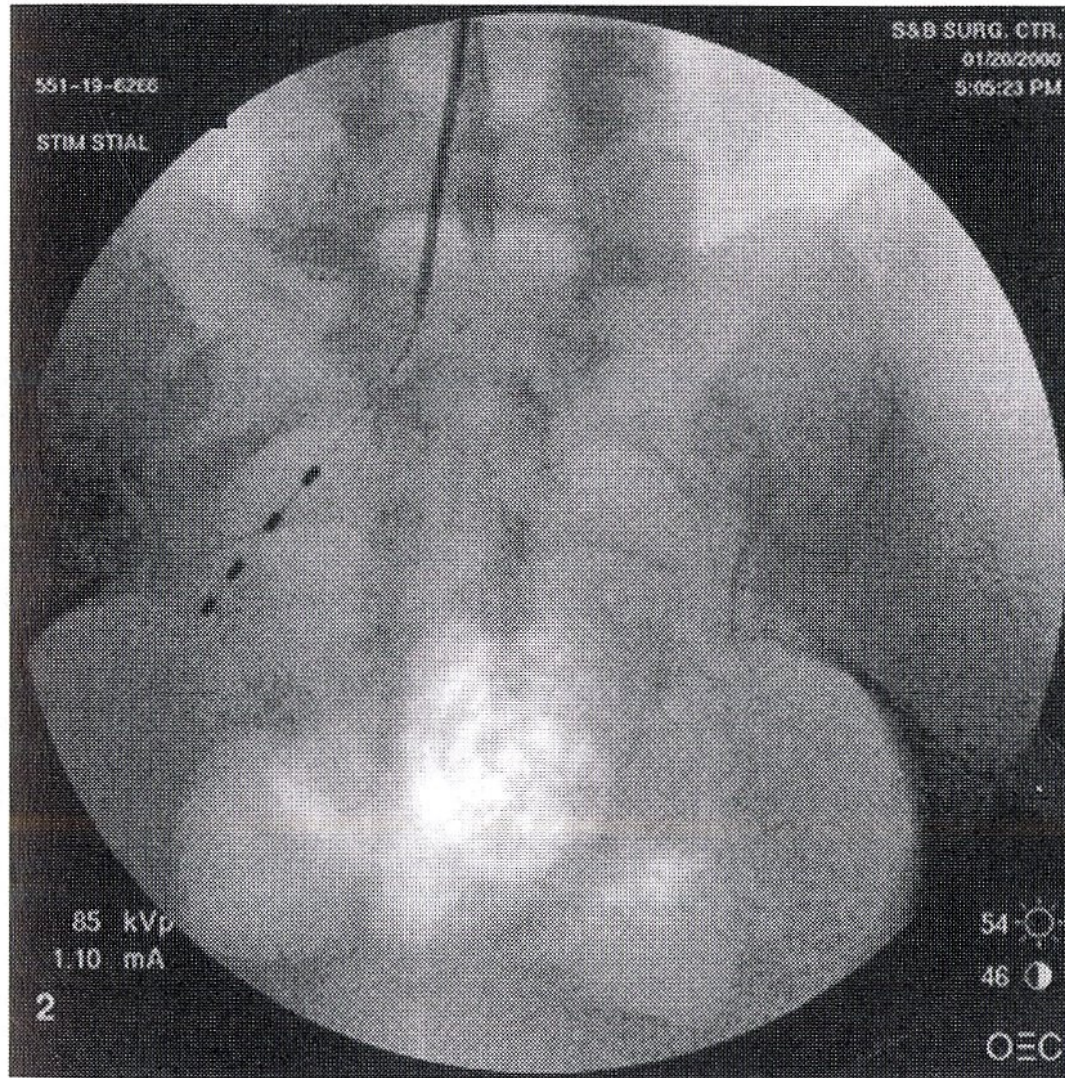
Radiograph showing retrograde placement of electrodes on the S3 and S4 roots for the management of pelvic pain.
